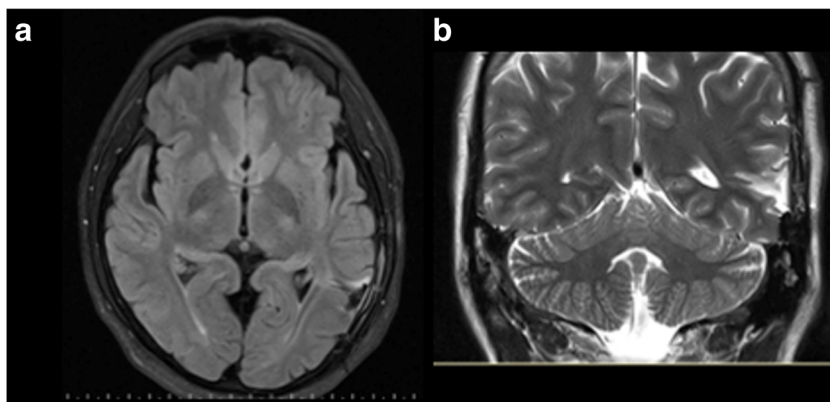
a–b Postoperative axial MRI showing an area of encephalomalacia involving the temporal lobe with subcortical gliosis without enhancement after contrast administration
